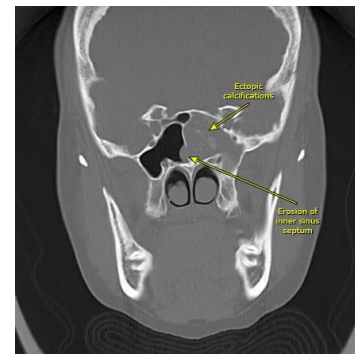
CT PNS coronal cut showing soft tissue mass left sphenoid sinus with hyperattenuation and bowing of intersinus septum
